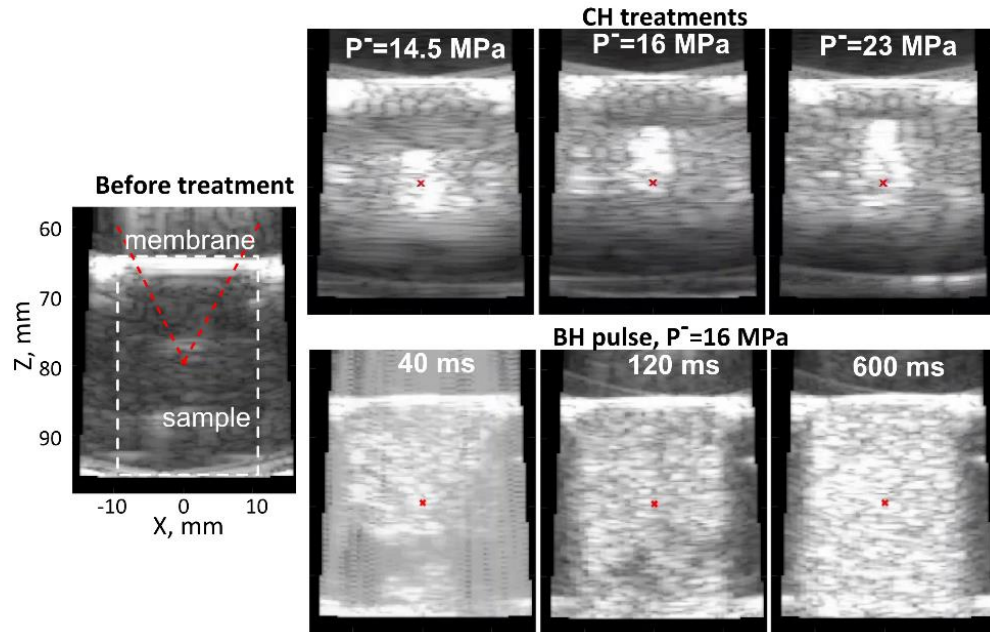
Representative B-mode ultrasound images observed during CH (top) and BH (bottom). The hyperechoic CH cavitation cloud was generally confined to the focal area; it slightly elongated and shifted pre-focally with the increase in p^- from 14.5 to 23 MPa. Conversely, following each BH pulse, hyperechoic bubbles filled the entire sample volume through visible streaming-induced mixing and persisted until the next pulse arrived. Note the high-intensity focused ultrasound reverberation artifact in the image immediately following the BH pulse (40 ms). BH: boiling histotripsy; CH: cavitation histotripsy.
